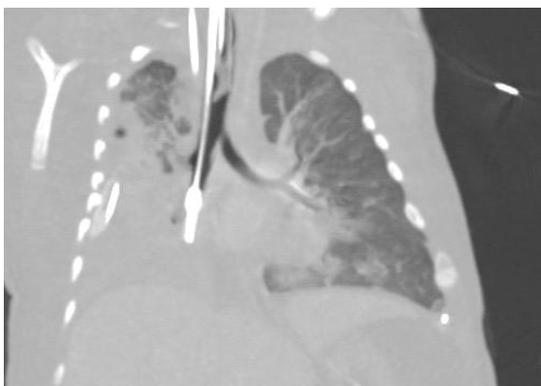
CT chest showing bronchial blocker placed below RUL bronchus.
